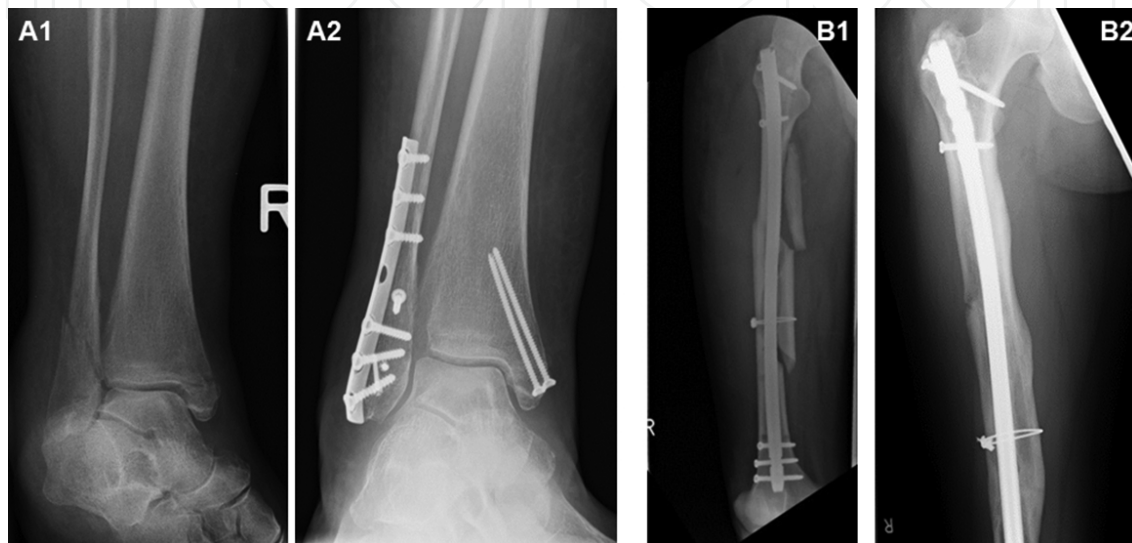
X-ray images from fracture patients: (A) fracture treated with an open reposition and internal fixation (ORIP) procedure with correct anatomical reconstruction of the fracture ends without fracture gap consistency—the bone will heal without callus formation through primary bone healing. (B) Comminuted fracture treated with an internal nail. Several gaps between the fractured bone ends remain and healing takes place by secondary bone healing as the callus visible in the image B2 taken 3 months after treatment clearly shows.
